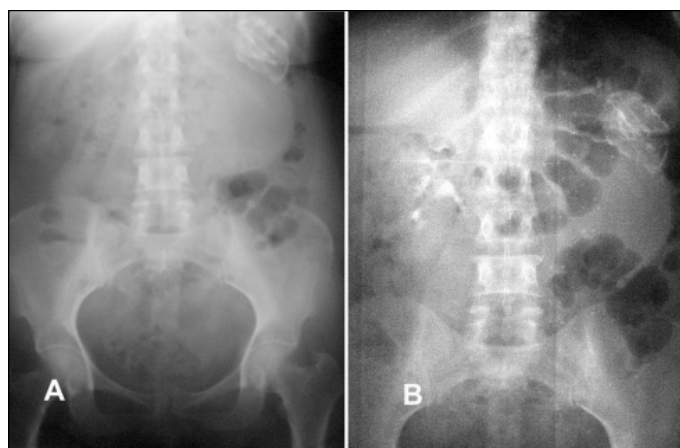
A. Plain x-ray reveals curvilinear calcifications; B. Excretory urography showed non excretion of contrast by the left kidney.
